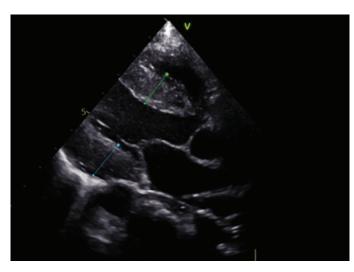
Transthoracic echocardiography in left parasternal view. The interventicular septum was 1.8 cm (green colour), posterior wall of the left ventricle (blue colour) was 1 cm. This is type of hypertrophic cardiomyopathy.
